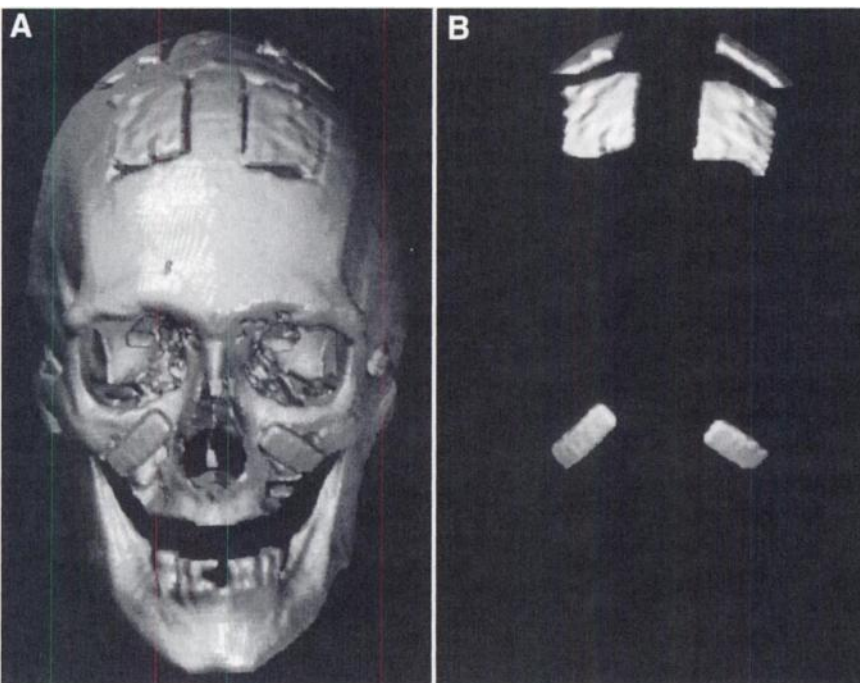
(A) Anterior view of 3-dimensional surface reconstruction of CT data from head 3. (B) Segmented CT VOIs for 4 inlay and 2 onlay grafts of head 3.
